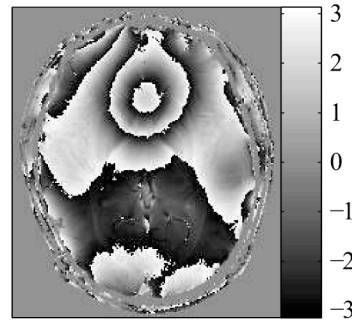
Axial slice of a complex-valued MRI volume. A) Magnitude component. B) Phase component. Due to field inhomogeneities, the phase component exhibits numerous phase discontinuities (wraps) between $-\pi$ and π .
